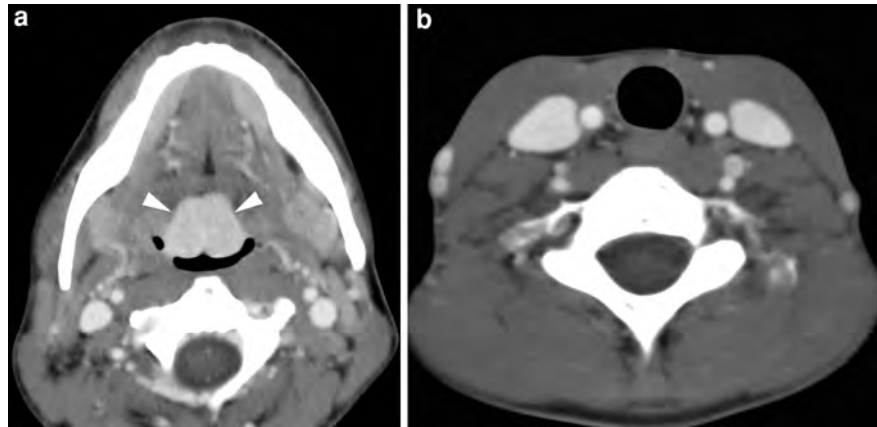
Axial contrast-enhanced CT image in a patient with a progressive neck swelling. Mass lesion (*arrowhead*) centered in and destructing the hyoid bone, with extension to surrounding structures, causing narrowing of the oropharyngeal airway. The lesion was resected; pathological study revealed papillary thyroid carcinoma, presumably arising from ectopic thyroid tissue. There was no evidence for a primary cancer in the thyroid gland
